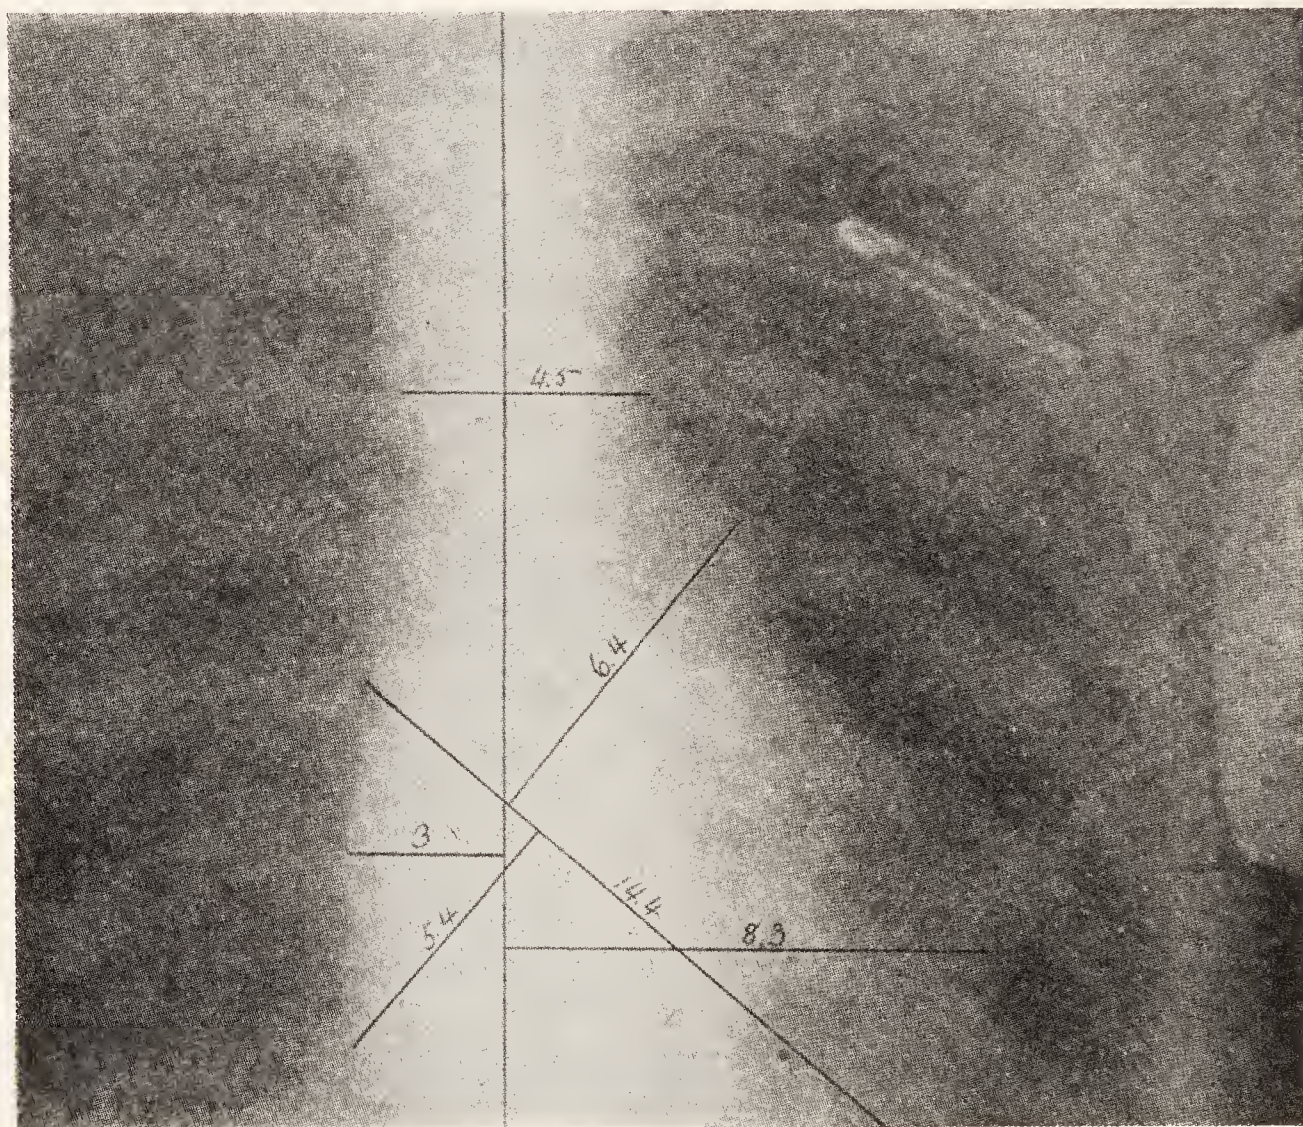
Cardiac shadow in Case LXIX. (Roentgenological Department, Massachusetts General Hospital.)
